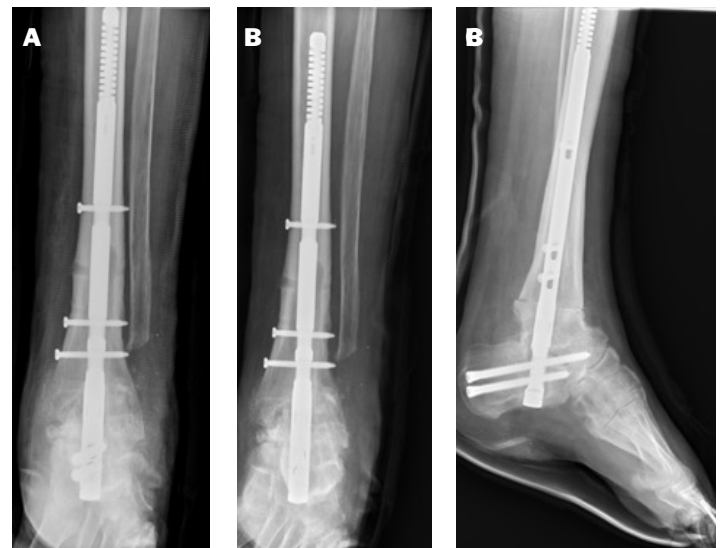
(A-C): Three NWB ankle radiographs post-op week two showing TTC fusion with tibial osteotomy. A. AP view B. Mortise view C. Lateral view
